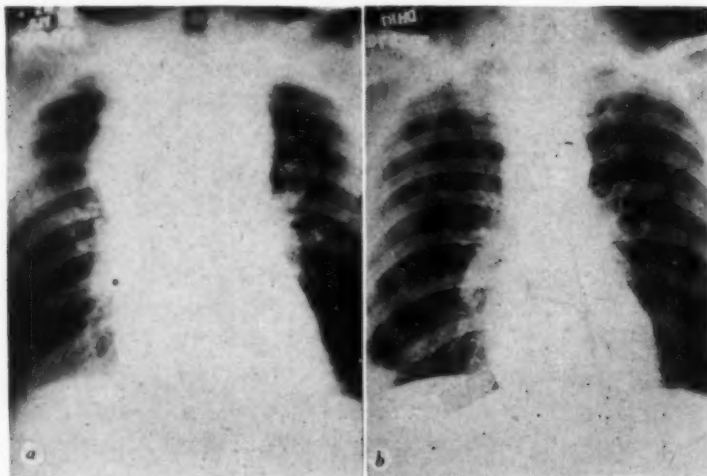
Roentgenograms of thorax in case 4.
